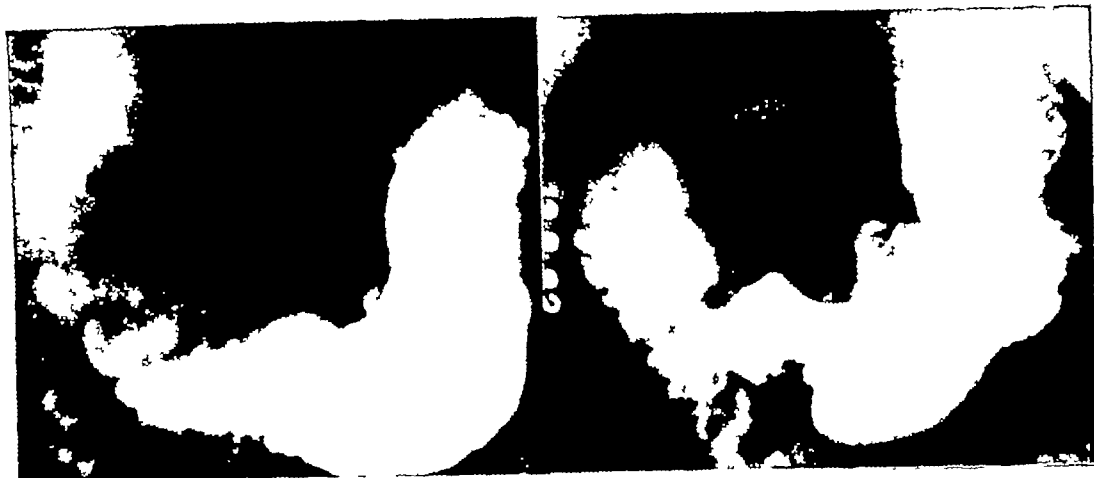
A Perforating ulcer on lesser curvature at the angle with the roentgenologic features of malignancy
